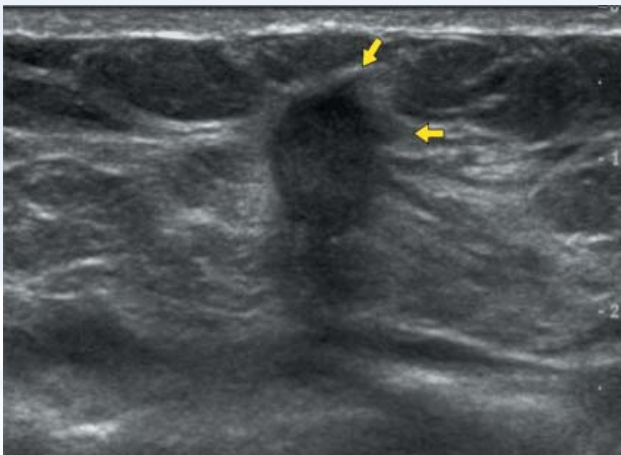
Angular margins are ominous signs for a mass and raise suspicion for malignancy. A 35 years old woman was referred for imaging after she felt a breast lump. Ultrasound shows a hypoechoic mass with angular margins (arrows). This was biopsied and found to be cancer
